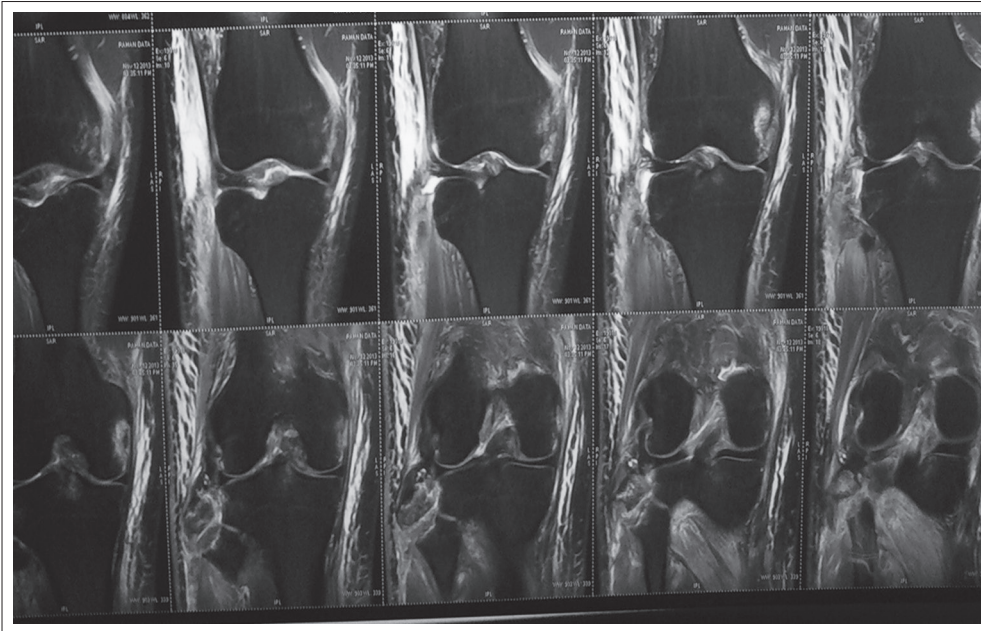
Magnetic resonance imaging section shows avulsion of the fibular head with soft-tissue edema around fibular neck.
